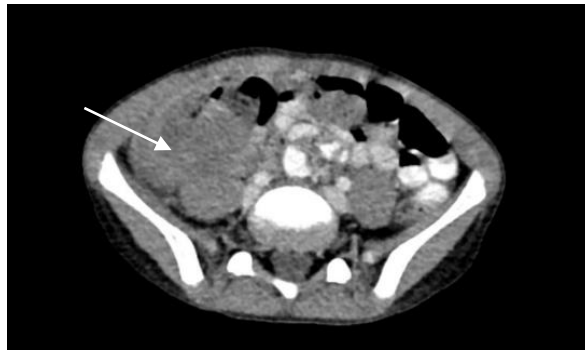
The initial abdominal CT scan showed an area of heterogeneous soft tissue density at the right lower quadrant posterior to the cecum. It spans about 4.2 x 1.5 x 3 cm in transverse, AP, and CC dimensions, respectively.
